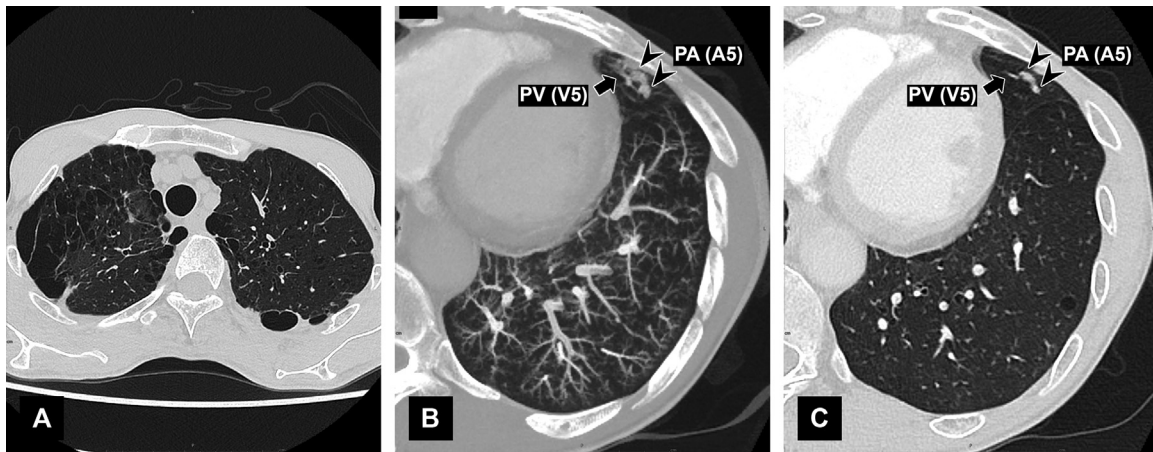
Plain computed tomography (CT) findings. Plain CT imaging reveals severe emphysema (A). The maximum intensity projection highlights a dilated and tortuous pulmonary artery (PA) A5 segment (arrowheads) in the lingula of the left lung leading to a bulbous, aneurysmal nodule with a well-defined border, adjacent to a nearby pulmonary vein (PV) V5 segment (arrow) (B). It is uncommon for pulmonary arteriovenous malformations to present with a dilated PA (arrowheads) while the PV (arrow) remains unaffected (C).
